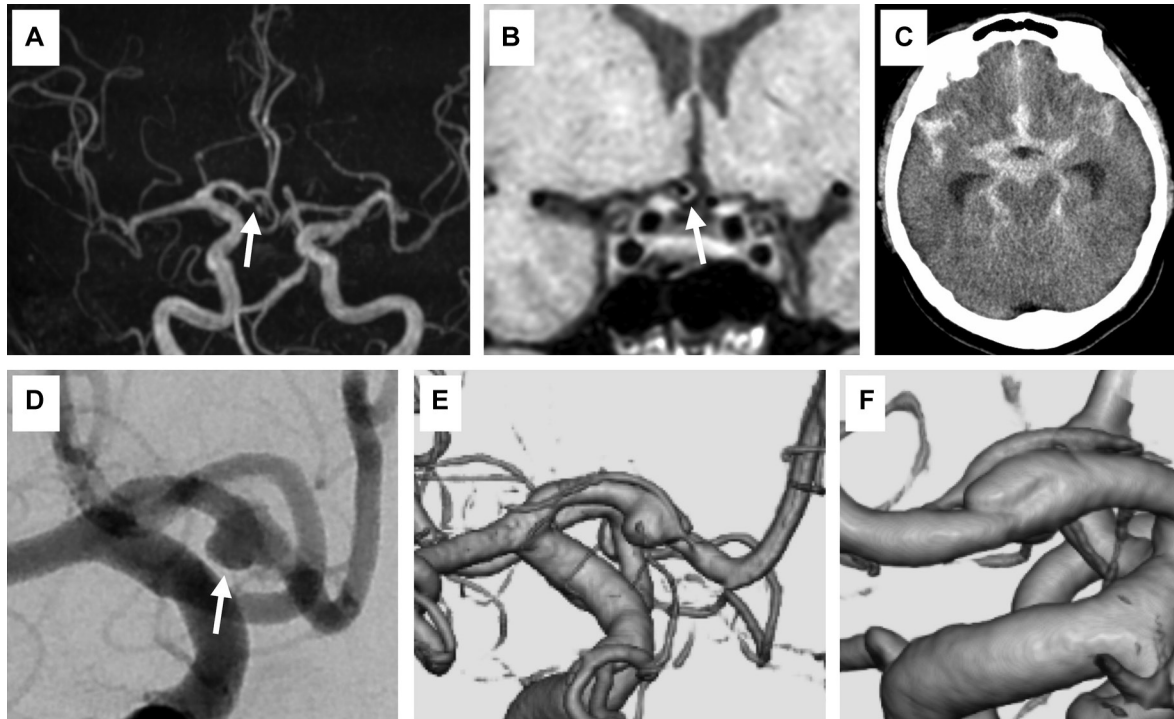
(A) No aneurysm was found on MRA at admission. Stenosis of the distal A1 was suspected (white arrow). (B) Simultaneous T1 black blood image showing the iso-intense thickened wall at the distal A1 (white arrow). (C) CT on the following day showing diffuse subarachnoid hemorrhage in the basal cistern. (D and E) Digital subtraction angiography and 3D rotational angiography of the left internal carotid artery demonstrated an A1 aneurysm (white arrow). (F) Medial view of 3D rotational angiography demonstrated the intimal flap and partially remaining normal vessel wall.
